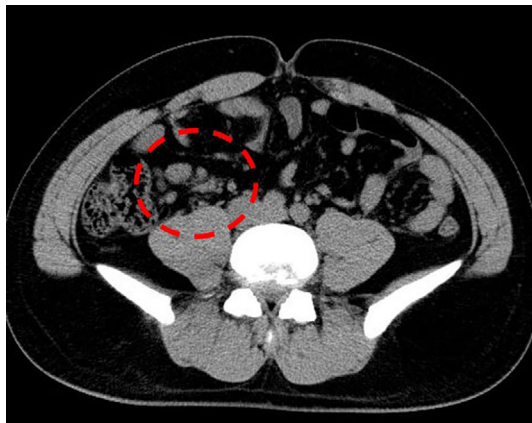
Abdominal computed tomography showing regional mesenteric lymphadenopathy.
